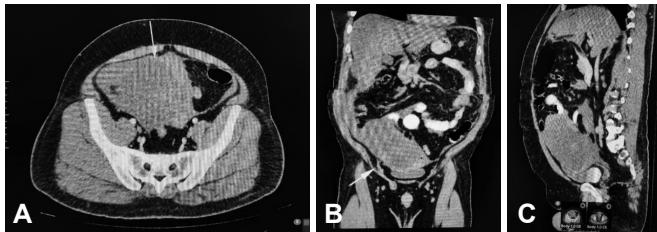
A, B and C): CT scan of axial, coronal and sagittal sections showing a heterogenous lesion seen in the right iliac fossa.
